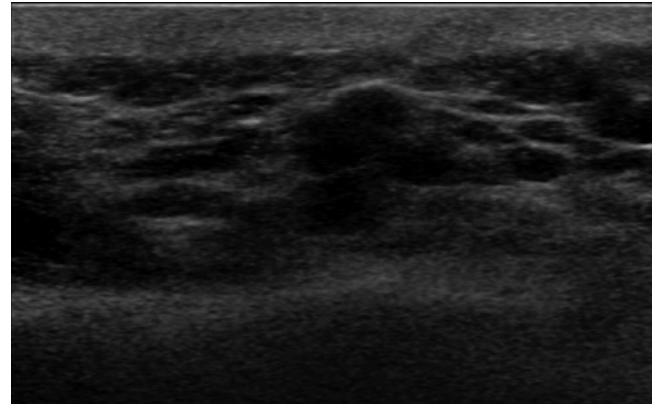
A 43-year-old woman with a palpable lesion after right mastectomy. Transverse sonography revealed a 12-mm-size hypoechoic nodule with round shape, indistinct margin and nonparallel orientation at the right chest wall. This lesion was assessed as category 4b, and US-guided fine-needle aspiration biopsy was performed. Pathology results were positive for malignancy. Surgical excision also revealed recurrent invasive ductal carcinoma
